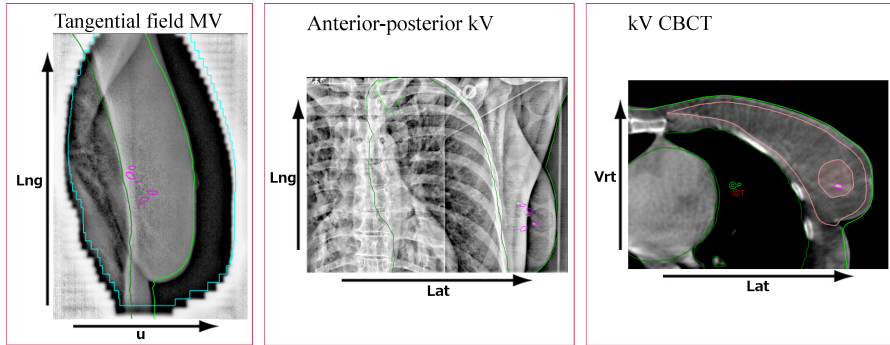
Different setup verification images. The images are registered to the planning CT and structures from planning CT are visualised. Clips are visible on kV images. The u direction is a linear combination of the lateral ($\approx 1/3$) and vertical ($\approx 2/3$) direction. Images from patient 12 fraction 2 from CRAM protocol (Described in section 3.1).
